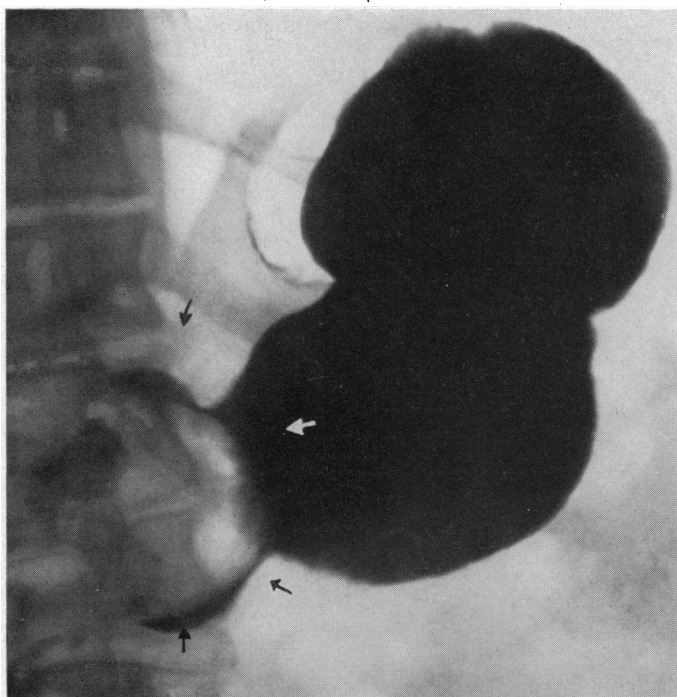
Case 4: Note large gastric defect as shown roentgenographically.
